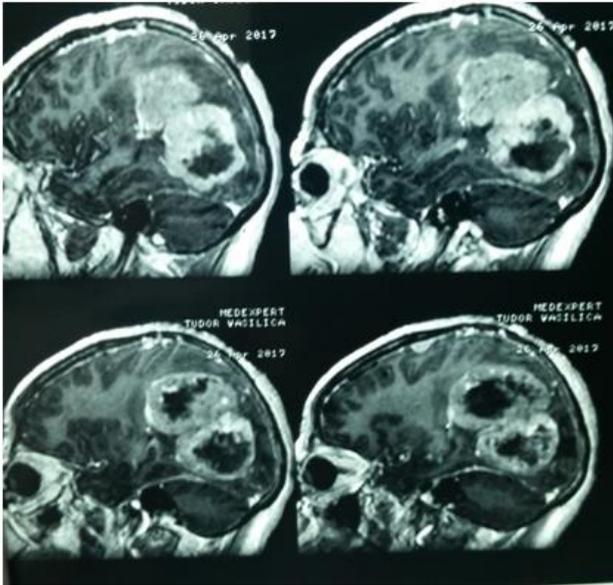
Preoperative enhanced CT- scan images, sagittal view
